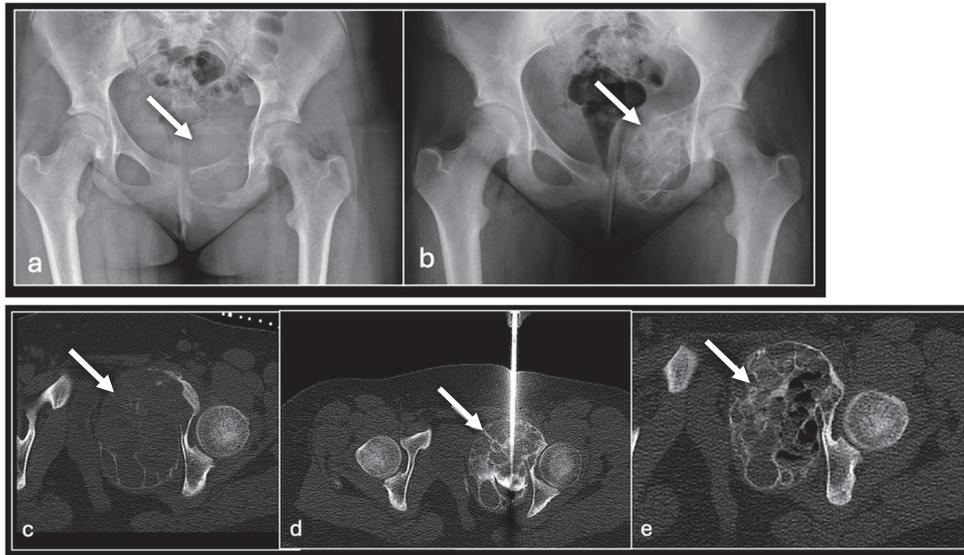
AP radiograph of pelvis (a) showing destructive lesion of left pubis and superior pubic ramus (arrow) with marked consolidation post three sessions of sclerotherapy (b). Axial CT imaging pre sclerotherapy (c), intraprocedural (d), and following three sessions of sclerotherapy (e) to the lesion (arrow).
